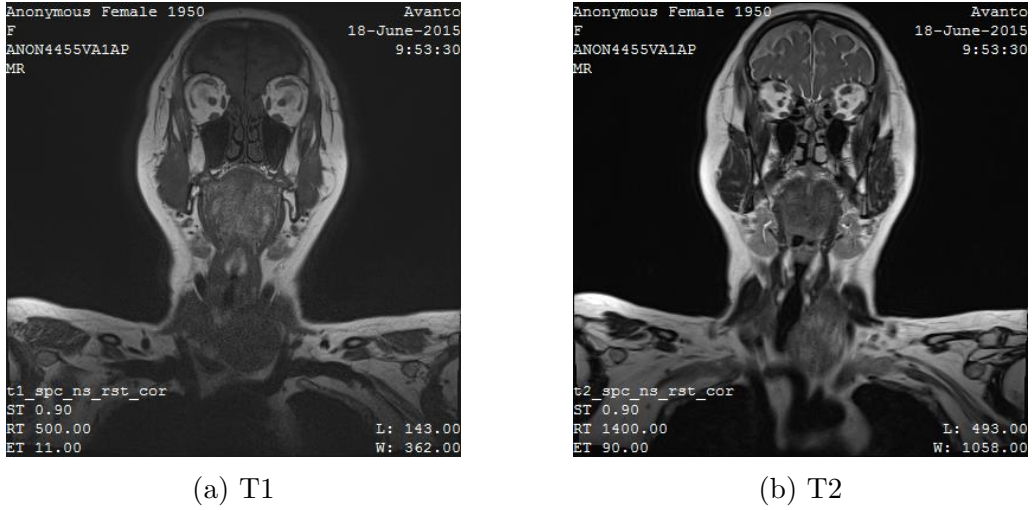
(a) and (b) show the difference between T1 and T2 weighted MRI images, respectively.
